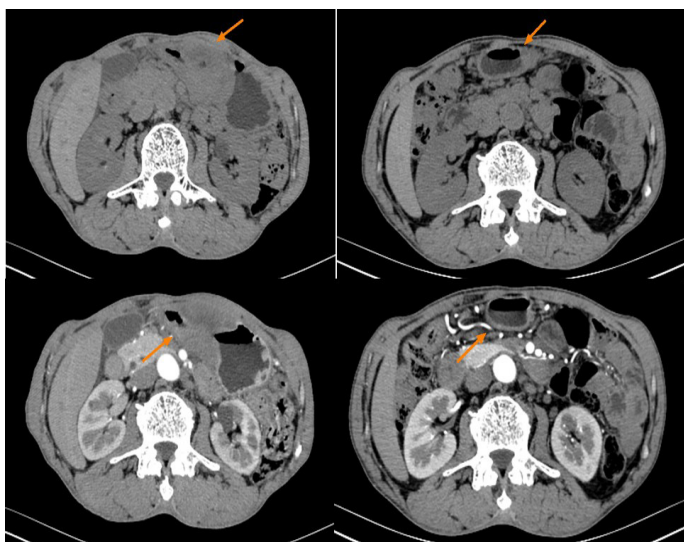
Computed tomography (CT) scan of abdomen Left image shows before infusion chemotherapy, Local gastric wall thickening in the gastric antrum, and it is mostly considered as a tumor lesion. The right image shows after infusion chemotherapy. The scope of the lesion was reduced compared with the previous one, and the degree of thickening was significantly reduced.
